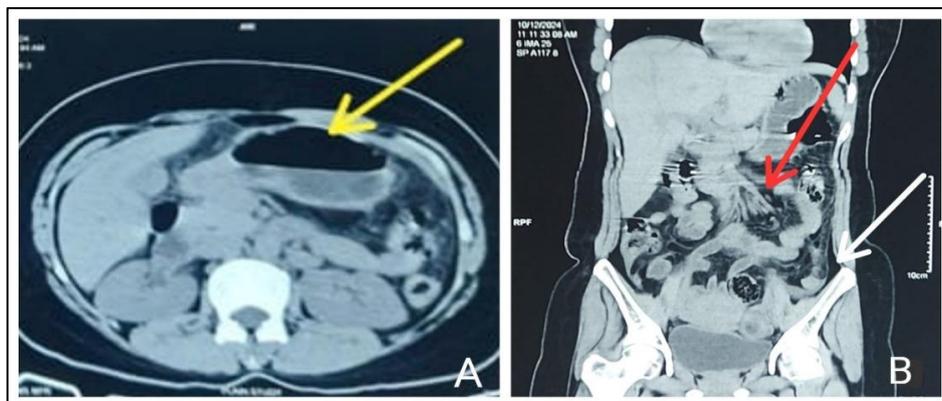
(A and B): A-an axial CT section at the level of the mid abdomen with dependent high attenuation fluid, filling the left paracolic gutter and non-dependent low attenuation fat seen in the anterior abdominal wall, forming a fat fluid level (yellow). This fluid was consistent with the lipid laden peritoneal fluid that was found on laparotomy. B-fat stranding (red) with fat collection intraabdominal in the dependent areas (white).
